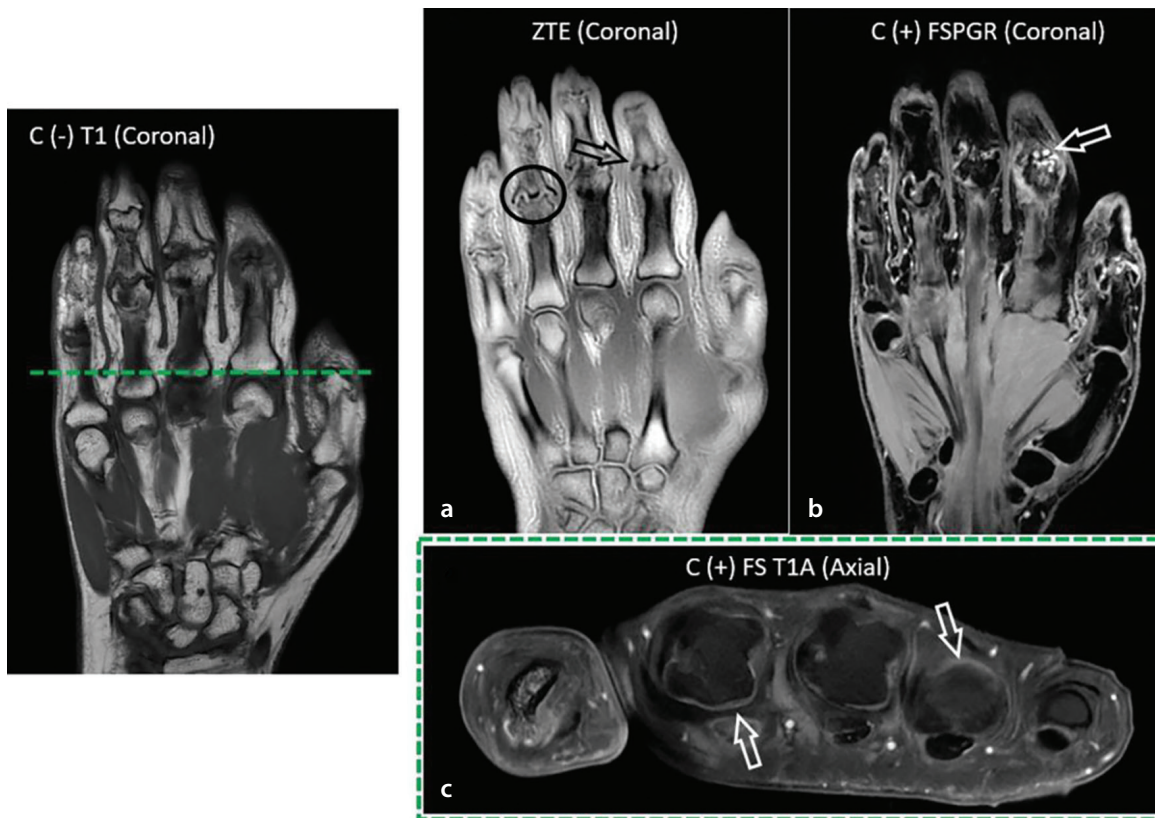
A case of inflammatory arthritis with predominantly degenerative findings. A 62-year-old female patient with a 12-month history of diffuse pain, more pronounced in the left hand. Magnetic resonance imaging (MRI) revealed marked joint space narrowing, prominent osteophytes (a, arrow), and subchondral cysts (b, arrow), most evident in the proximal interphalangeal joints. Gull-wing appearance (a, circle), secondary to central erosions, was also observed. An axial section at the metacarpophalangeal joint level showed mild synovitis (c, arrows). Based on these MRI findings, suggesting degenerative coexisting with inflammatory features, the patient was diagnosed with erosive osteoarthritis. ZTE, zero time to echo; C+, contrast enhanced; C-, contrast non-enhanced; FS, fat saturated; FSPGR, fast spoiled gradient recalled echo.
